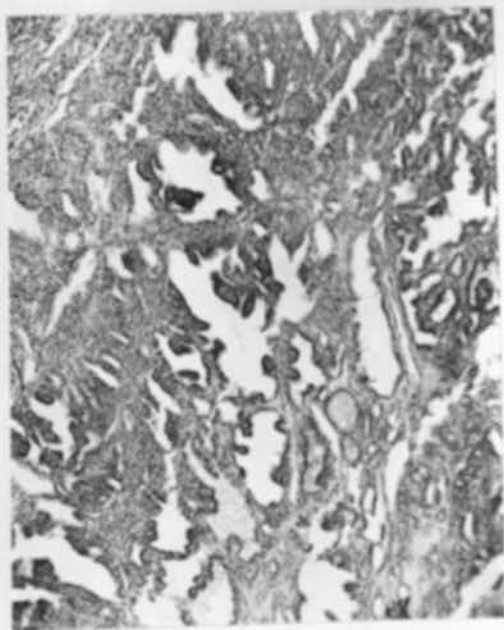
"Cured by X-ray". This case gave a five-year history of exophthalmic goiter. Many X-ray treatments had been given and a cure supposedly obtained. Persistent symptoms of hyperthyroidism and the evidence of hyperplasia show that a cure was not obtained.
